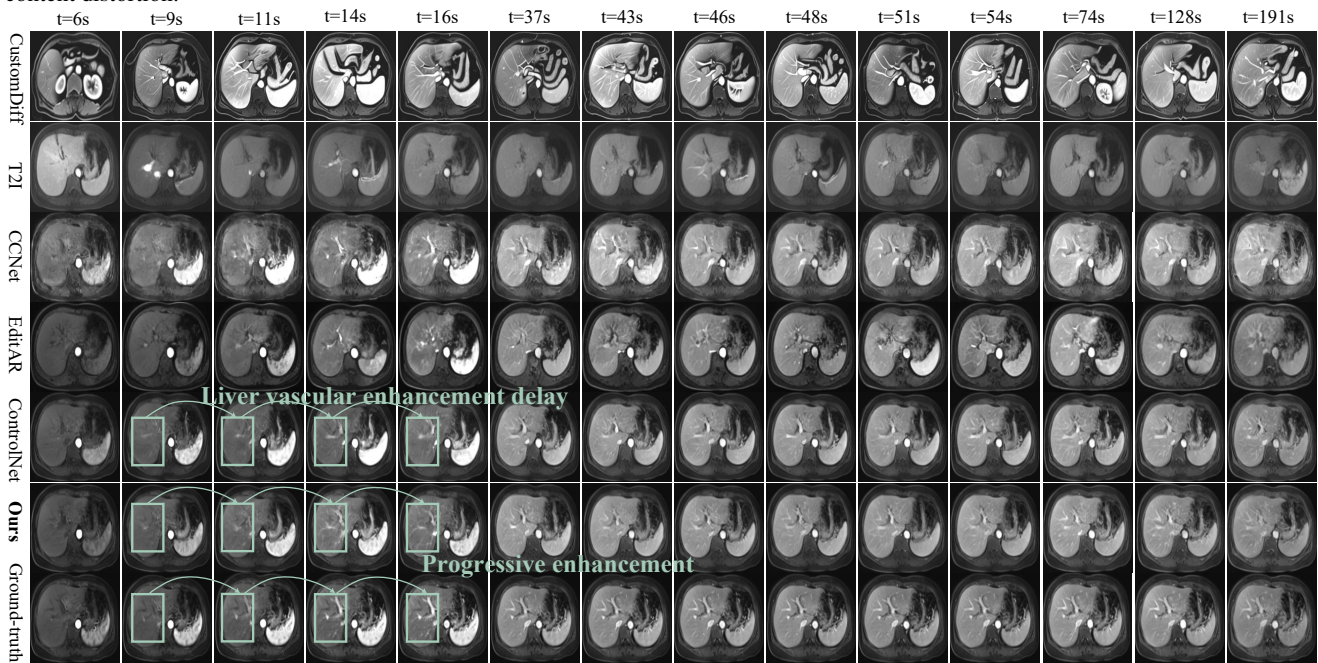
Visualization results of liver in Abdominal DCE-MRI shows that our CEKWorld conforms to the contrast agent kinetic laws of hepatic vessel progressive enhancement and liver parenchyma's regular enhancement-washout. In contrast, other methods exhibit distorted contents, while ControlNet suffers from non-physiological hepatic vessel enhancement delay, confirming our spatiotemporal consistency learning accurately captures liver contrast agent kinetics.
